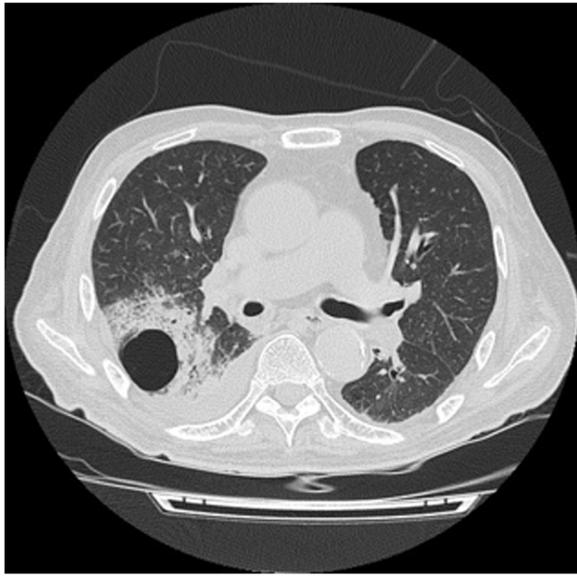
Plain computed tomography of the chest in case 1 showed cavity lesion in the right lower lobe
